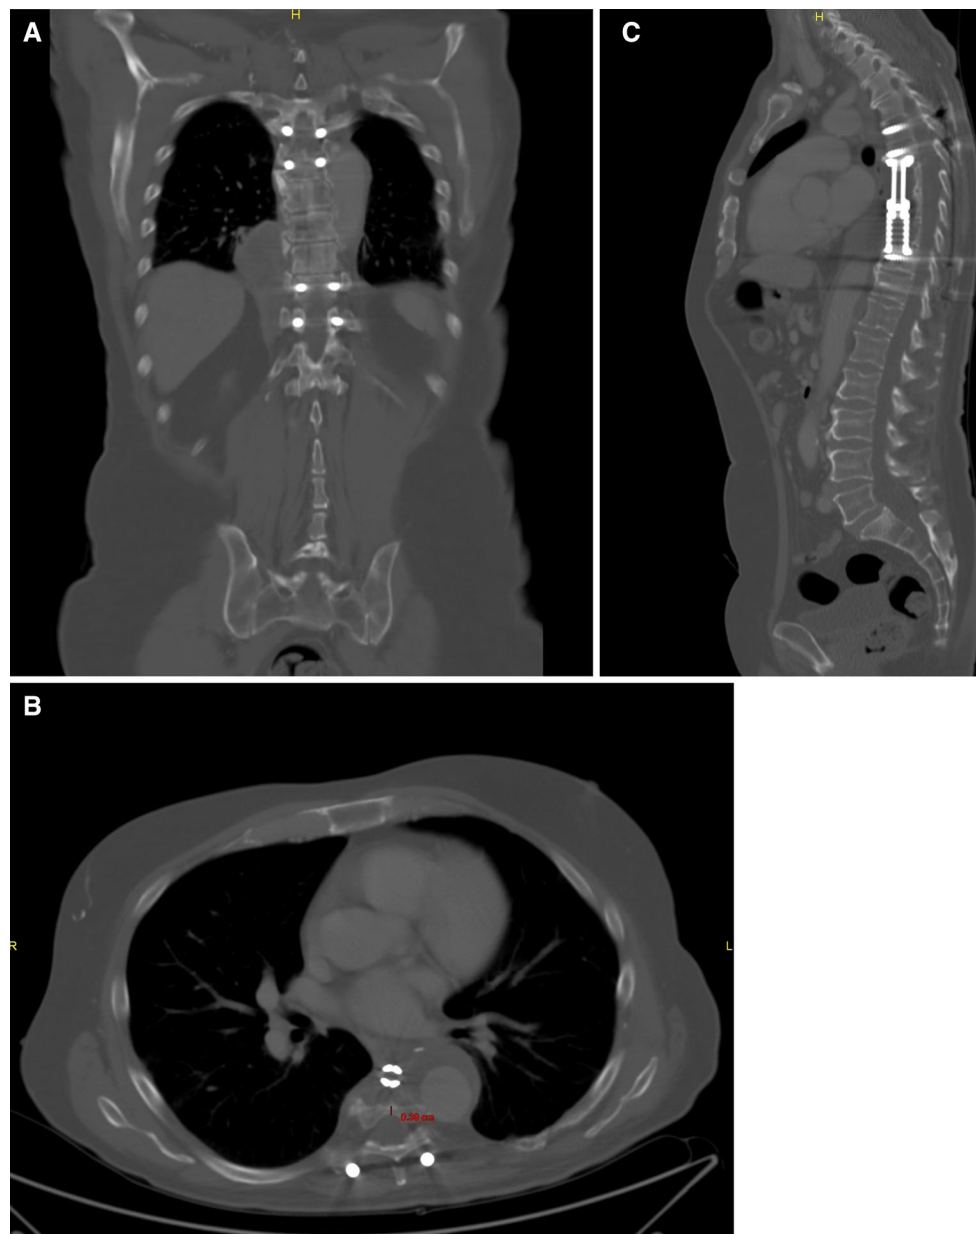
Postoperative CT scan. Coronal plane (a), transverse plane (b), and sagittal plane (c)
